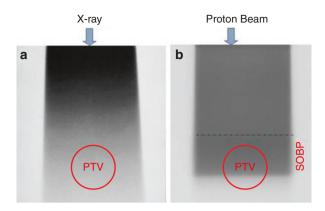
Dose distribution in 2D plane is shown on a radiographic film (a) photon beam and (b) proton beam. Note uniform dose in PTV with proton beam
